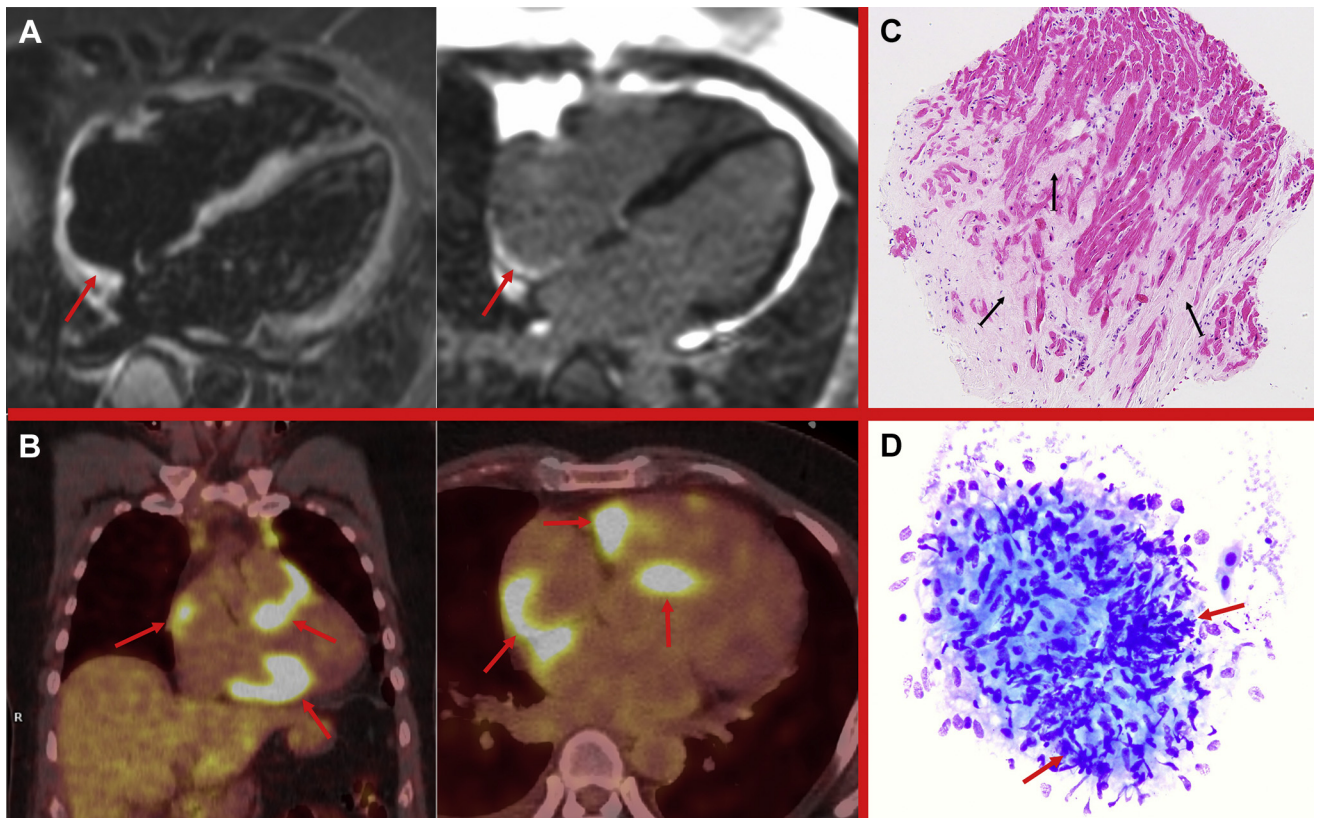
A: Cardiac magnetic resonance imaging showing T2 hyperintensity (left) and late gadolinium enhancement (right) of the right atrium (arrows). B: 18F-FDG positron emission tomography with marked multichamber hypermetabolism in the septal and lateral left ventricular walls, basal inferior right ventricle, and posterior right and left atrium (red arrows). C: Right ventricle myocardial biopsy demonstrating patchy stromal fibrosis (black arrows). D: Cytology of fine needle aspiration biopsy of paratracheal lymph node demonstrating epithelioid granuloma (red arrows) highlighting histiocytes.
